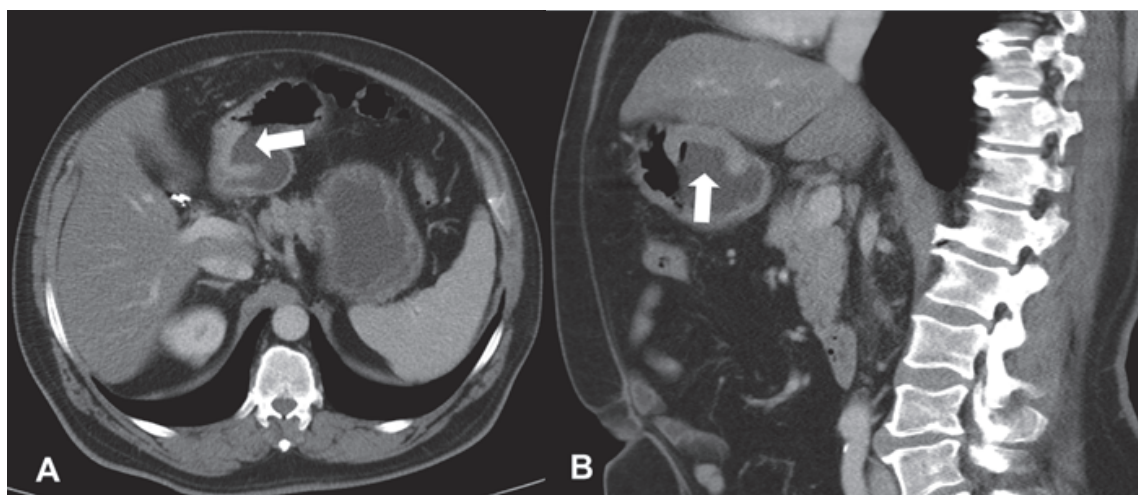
Gastric carcinoma located on the antro-pyloric tract. A. CT transverse scan. B. CT reconstruction on sagittal plane. The tumor causes a focal area of irregular wall thickening with ulcerative features (arrows). Stomach has been distended by water.
